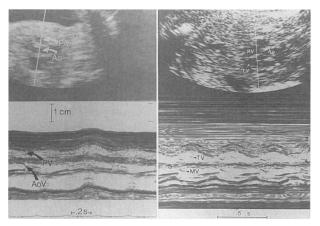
Real-time-directed M-mode ultrasonogram allows an assessment of the timing of atrial and ventricular events. Left, In the top frame, the M-mode cursor has been passed through the fetal thorax, the pulmonary artery (PA) and its valve, the aorta (Ao) and its valve (arrows), and the left atrium posteriorly. The bottom frame shows the opening of the aortic valve (AoV) and the pulmonary valve (PV) within their respective ventricles. The left atrium and the corresponding atrial contraction can be seen by the changing size of the left atrium as contributed to by the left atrial wall contraction. Right, In the top frame the Mmode cursor line crosses the right (RV) and left ventricle (LV) seen in long axis. In the bottom frame, the M-mode recording shows normal movement of both ventricular walls in systole. Tricuspid (TV) and mitral valve (MV) motion is also seen. The ventricular septum (S) and both ventricular free walls have about the same thickness (from Schmidt and Silverman<sup>48</sup>).
